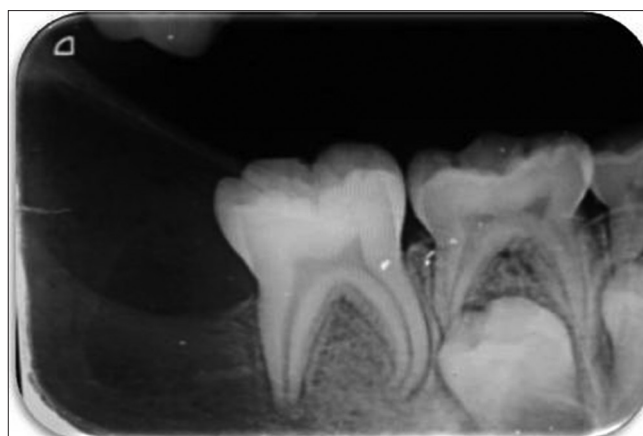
Intraoral periapical radiograph showing diffuse radiolucency distal to 46 with the absence of 47 tooth bud
